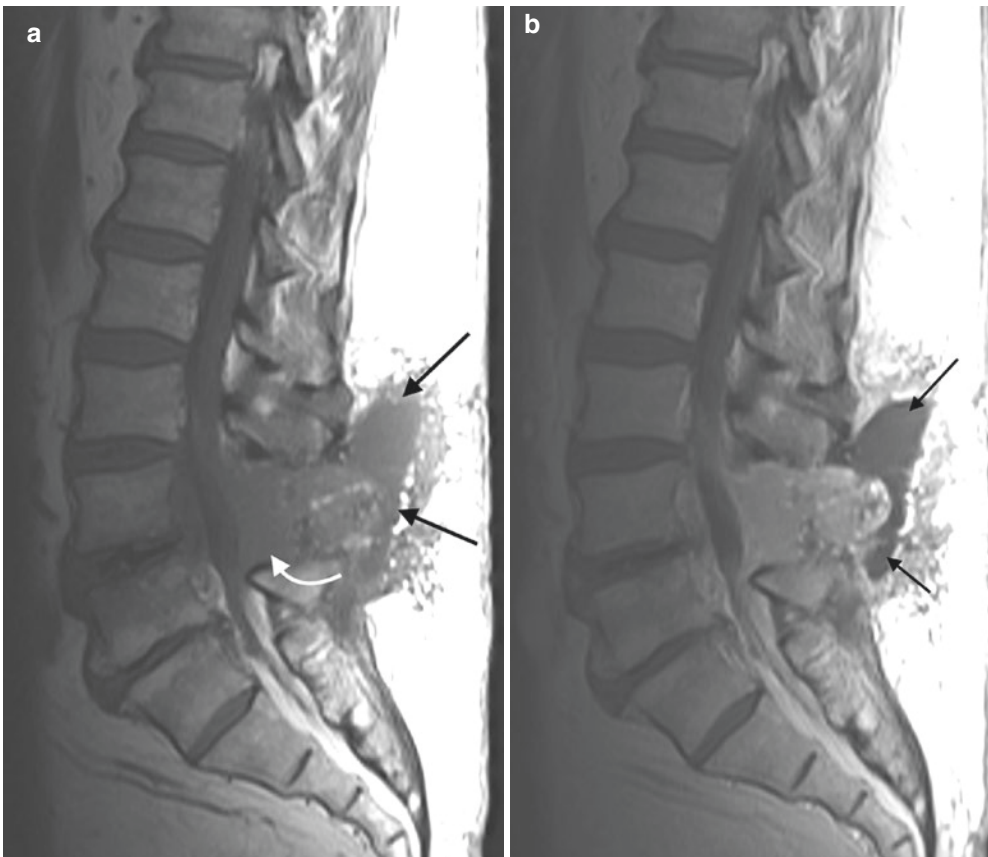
A 53-year-old female with fever and back pain presenting for fluoroscopic-guided aspiration of the L4-L5 disk space, previously noted to be abnormal on an MRI study. The patient is status post extensive spinal
